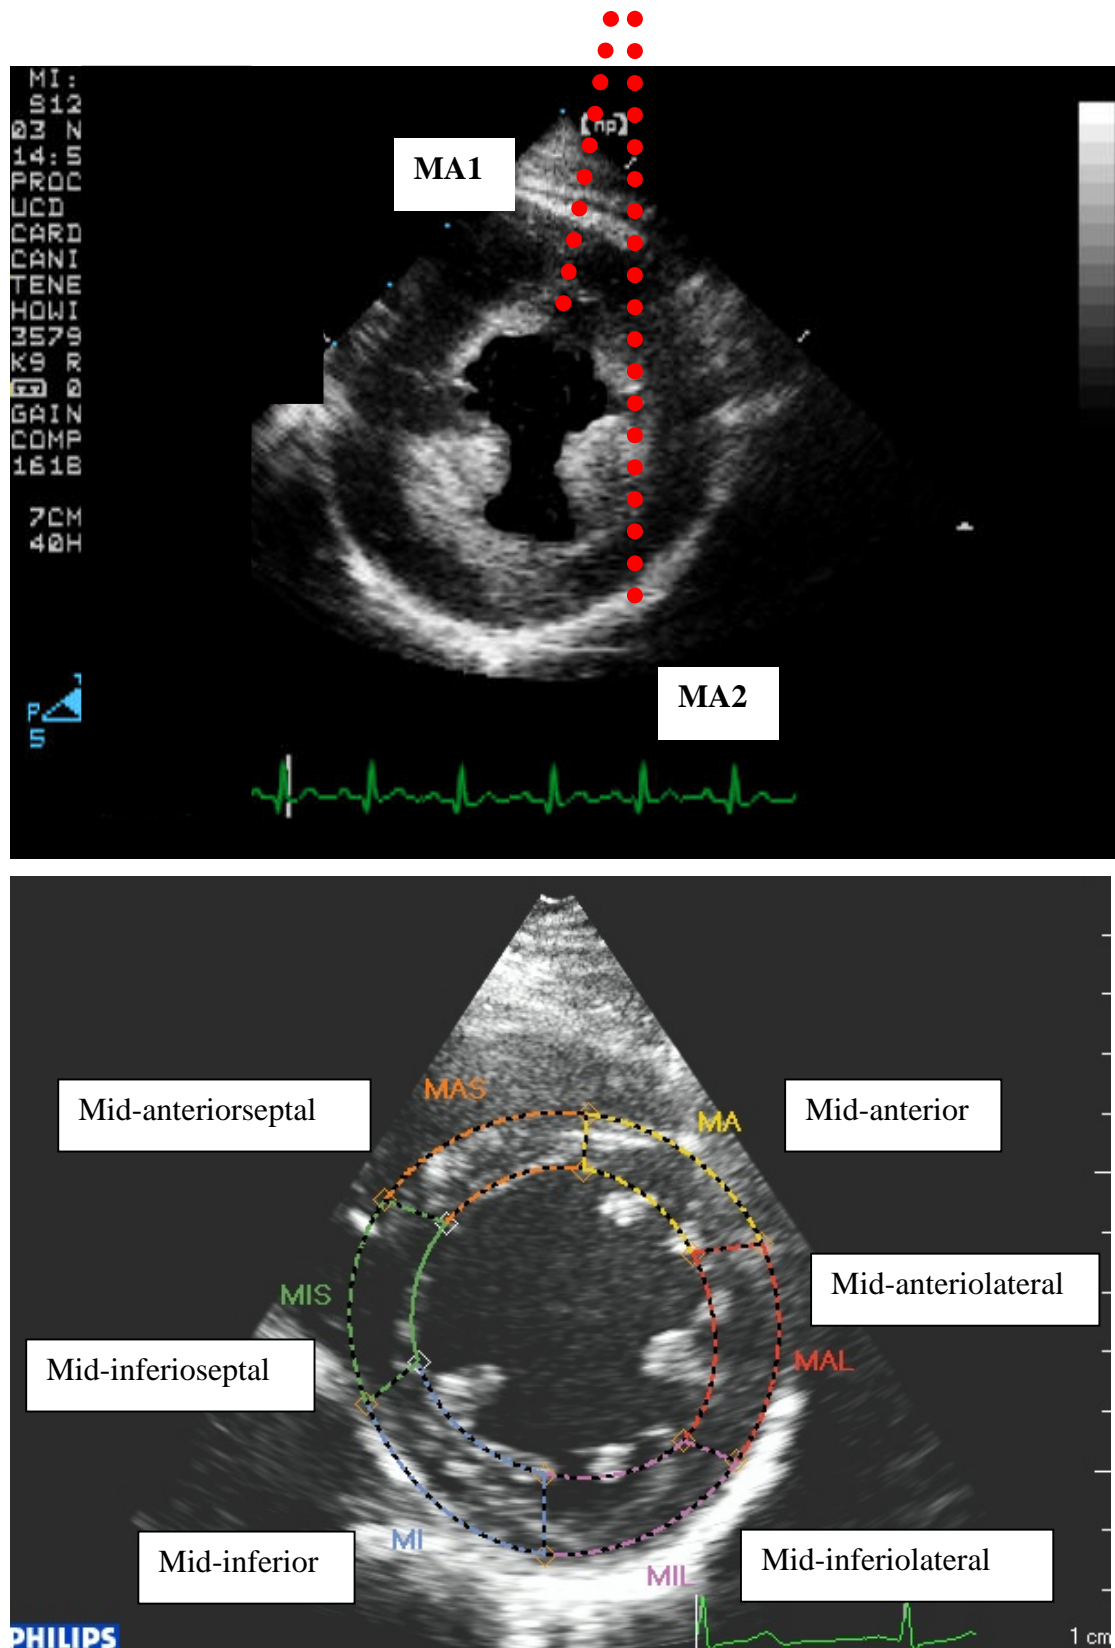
An example of the left ventricle myocardium taken from the parasternal short axis view at mid-level. The pulse-wave Doppler beam is placed over the anterioseptal and inferiolateral walls. Velocity of radial wall movement towards the centre of the ventricular cavity is measured and presented as a typical tissue Doppler trace.
